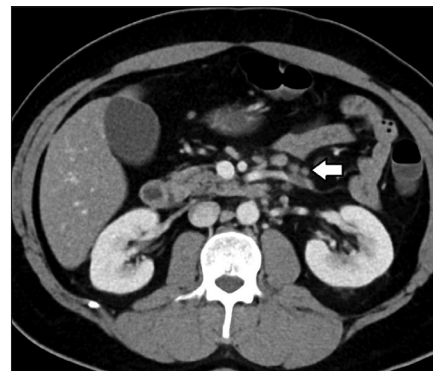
Axial CT image through the abdomen in a patient with sclerosing mesenteritis shows mesenteric fat stranding, haziness, and a few adjacent enlarged mesenteric lymph nodes (*left arrow*).
